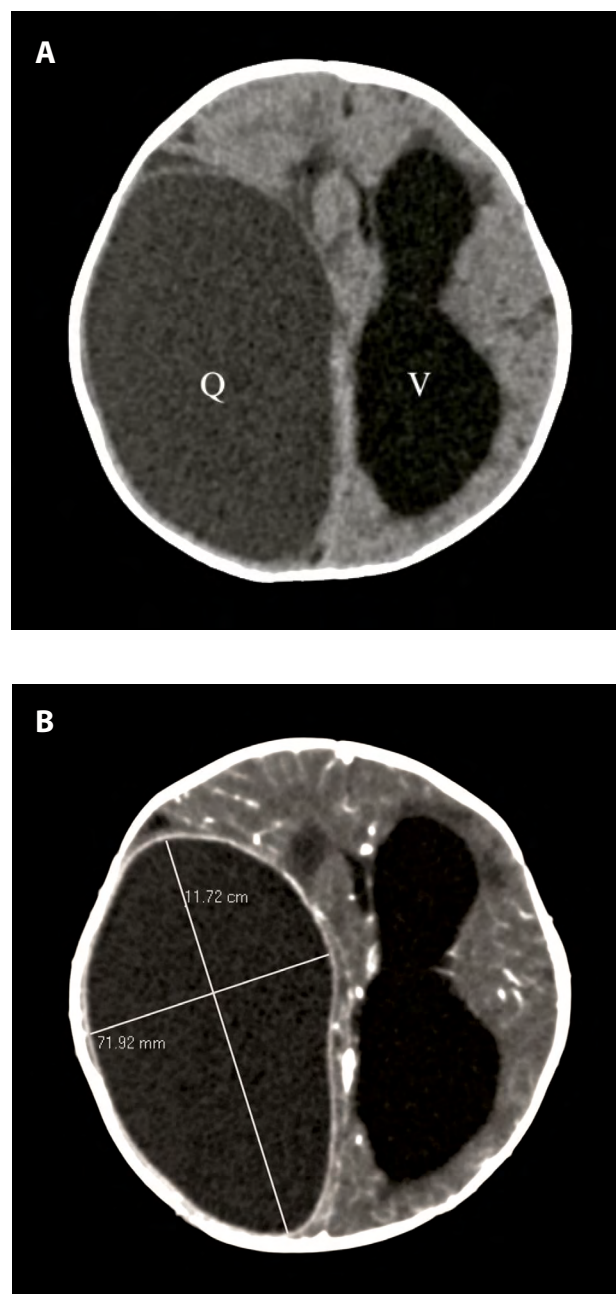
Axial brain CT showing an extensive cystic lesion (Q) in the right cerebral hemisphere. Panel A shows collapse of the right ventricle (V), dilation of the left ventricle, and midline shift. Panel B shows the cyst dimensions and posterior wall enhancement after contrast administration (CTDI: 60 mGy).
